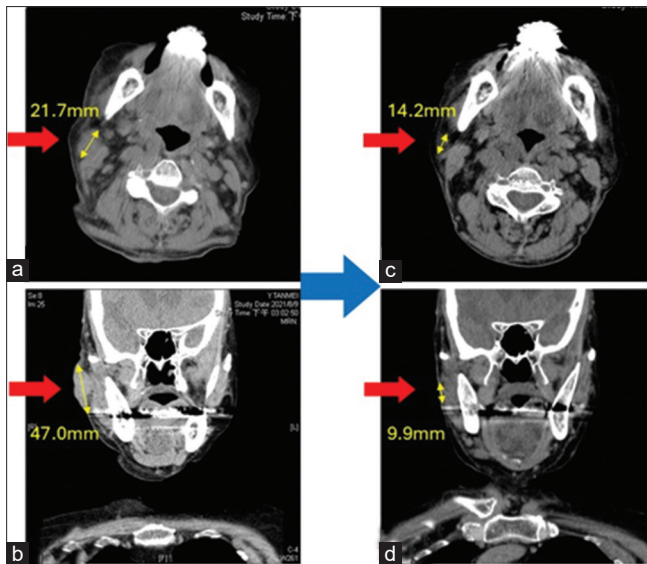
(a and b) Computed tomography of head and neck (H and N CT) before initiating nivolumab. A broad-based cutaneous plaque is noted on the right cheek. (c and d) H and N CT 6 months after the beginning of treatment. Partial remission is depicted by the reduction in tumor size of >75%. The arrows indicate the tumors
